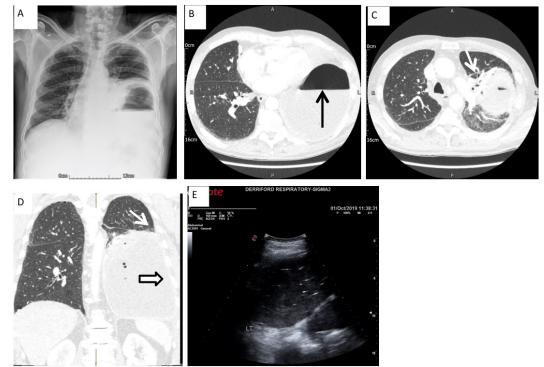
Before percutaneous intervention. (A) Chest radiograph showing a left-sided cavity with air-fluid level and tracheal deviation to the right. (B) Baseline chest CT with contrast, axial cut shows large 16 cm fluid and gas containing cavity occupying most of the left hemithorax with an air-fluid level as shown. (C) Chest CT with contrast, axial cut showing obtuse angle with the lung above the left hilar region and distortion of the pulmonary vasculature and airways (arrow). (D) Baseline chest CT with contrast, coronal cut showing large left collection that is making an acute angle with the chest wall (arrow) and the uniformly thin wall with smooth margins (hollow arrow). (E) Thoracic ultrasound shows multiple hyperechoic shadows inside an echogenic collection above an inverted diaphragm.
